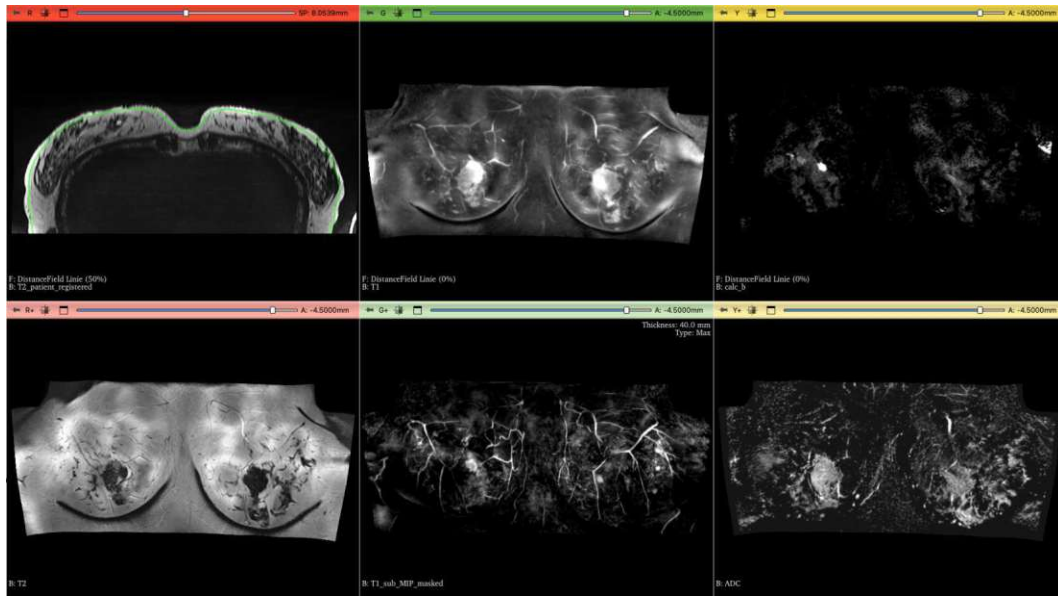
Setup 3.1: Evaluation of the surface-cutting approach. Hanging protocol composed of a T2 axial reference (the top left), while the remaining five panels showed coronal flattened versions of different sequences (T1 post-contrast, calc B, T2-weighted, T1 subtracted, and ADC).
